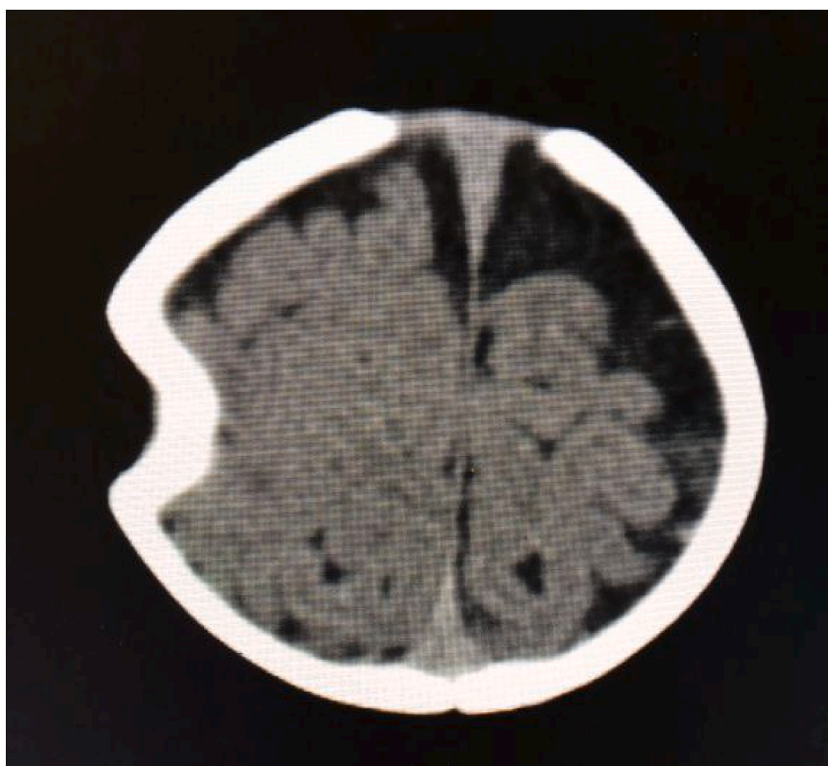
an axial CT scan of a 9 month old infant presented with motor vehicle collision (he was a passenger inside the car) showing a 'Ping-pong' depression of the skull bone.
